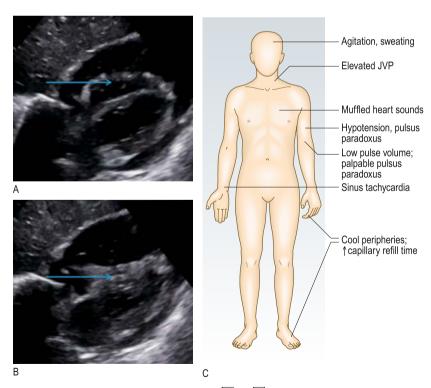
Clinical and echocardiographic features of cardiac tamponade. A and B Echocardiographic images taken from the subcostal position at the onset of systole (A) and in early diastole (B). The right ventricle (arrows) is collapsed in the early phase of diastole due to the elevated intrapericardial pressure; this is an important echo finding in tamponade. In both images there is a large pericardial effusion adjacent to the right ventricle. C Clinical features. JVP, jugular venous pressure.
